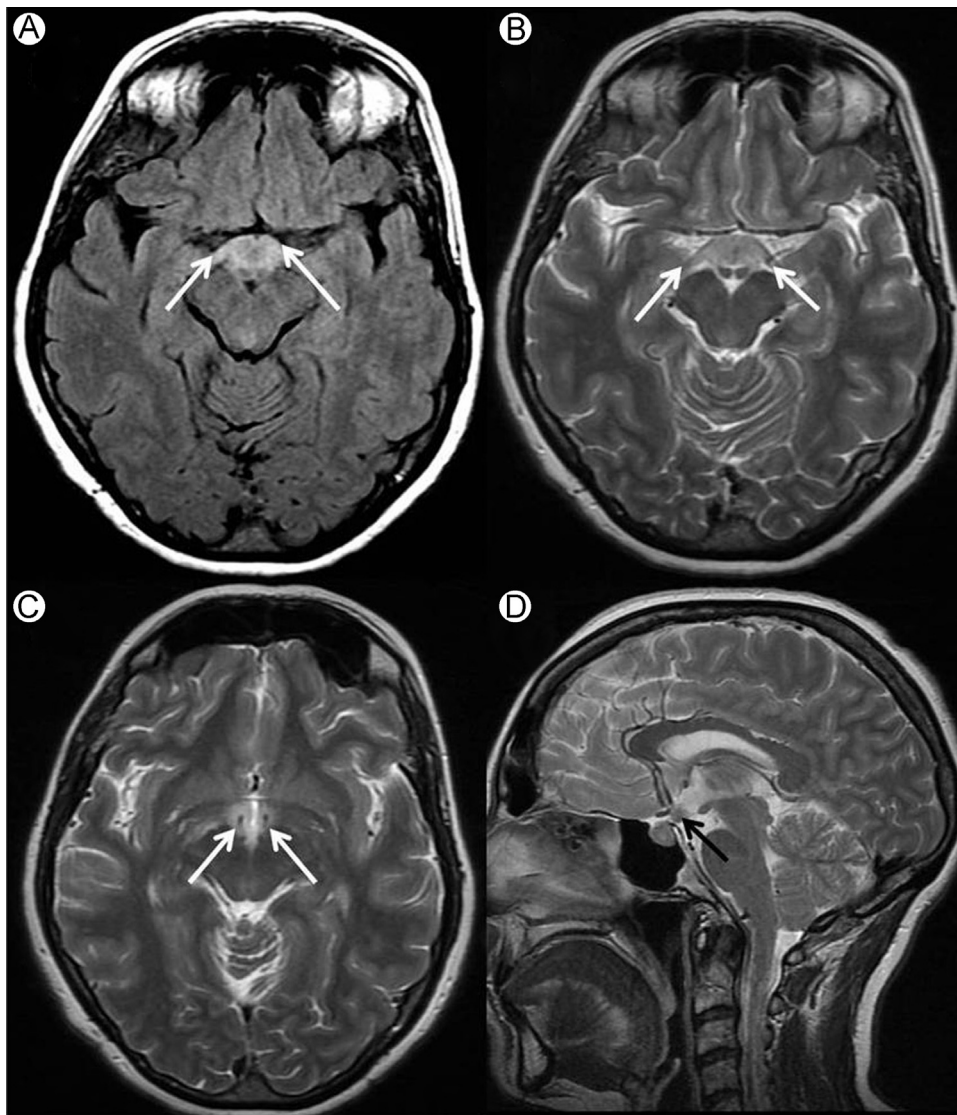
A patient with metastatic breast cancer presenting with diabetes insipidus and visual impairment: (A) axial FLAIR; (B and C) axial T2-weighted; and (D) sagittal T2 images. There is edema in the optic tracts (arrows, A and B) and hypothalamic edema outlining the anterior columns of the fornix (arrows, C), due to a T2 hypointense metastasis in the anteroinferior third ventricle (arrow, D). FLAIR, fluid-attenuated inversion recovery.
